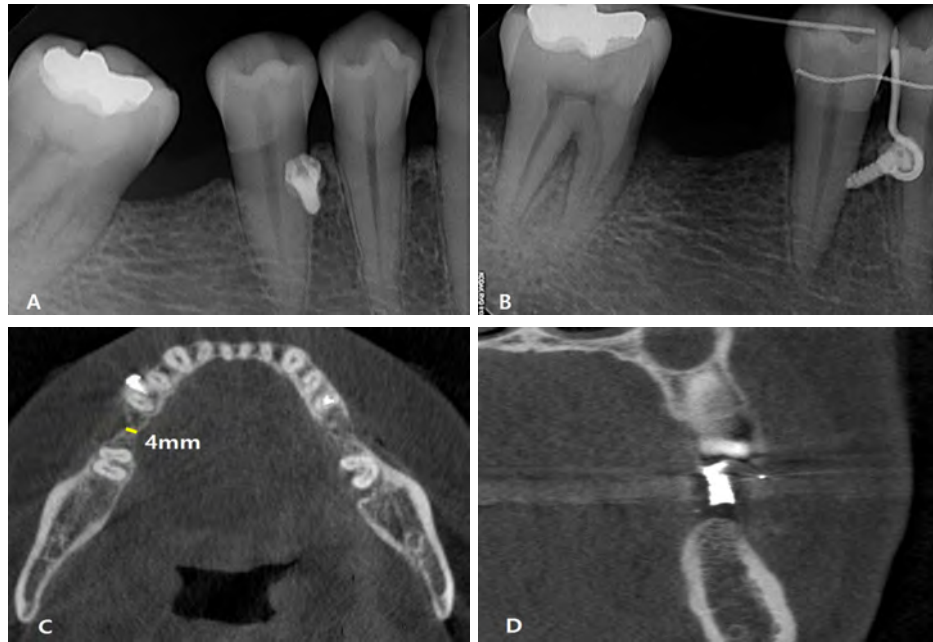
Progress periapical radiographs and preoperative CBCT. (A) Before uprighting. (B) After 8 months of appliance delivery. (C) An axial view of preoperative CBCT revealed an atrophied ridge on the buccal side of the mandibular right first molar region. (D) Coronal view with a surgical stent.
